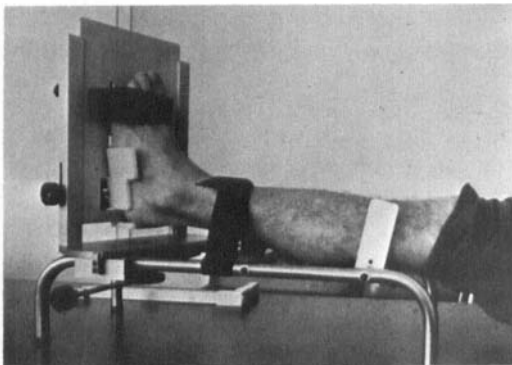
The stress X-ray examination frame used in the study.
